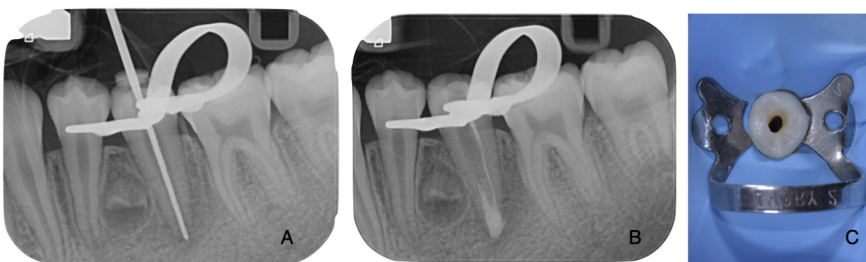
Series of intraoperative periapical radiographs documenting the working length confirmed radiographically (A), the apexification procedure with Mineral Trioxide Aggregate (MTA) apical plug, with a clear view of the supernumerary premolar (B). Proper isolation of the field with rubber dam is visible (C).
